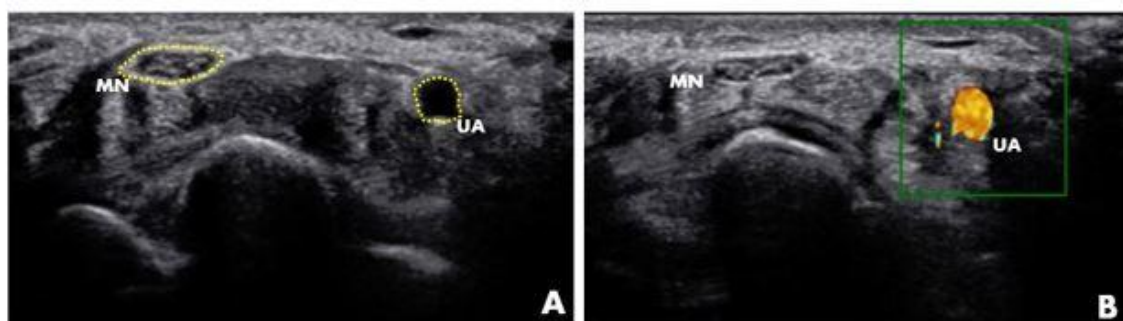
Sonographic view of median nerve and ulnar artery at the wrist crease. A: CSA measurement of MN and UA B: color Doppler image of UA CSA = cross sectional area; MN = median nerve; UA = ulnar artery
